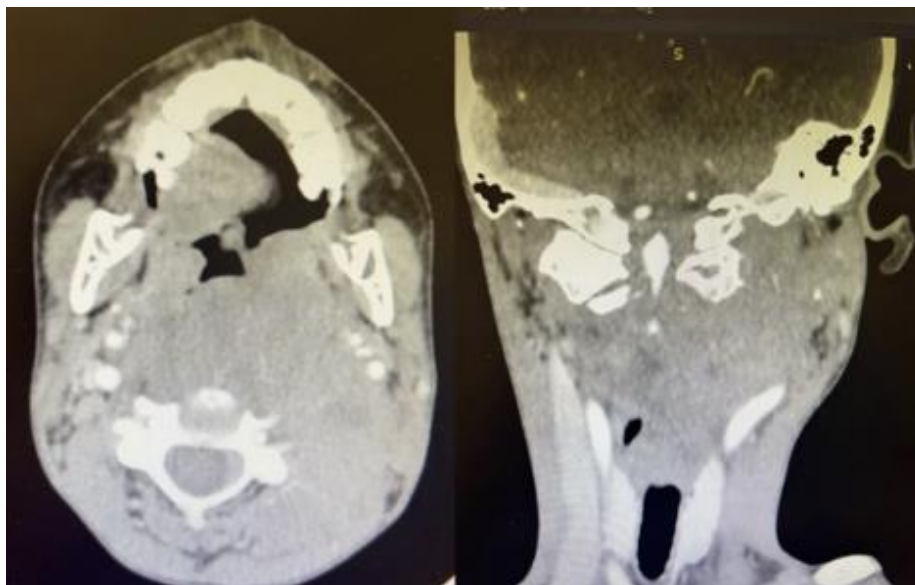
CT images demonstrating tumor progression and worsening mass effect
